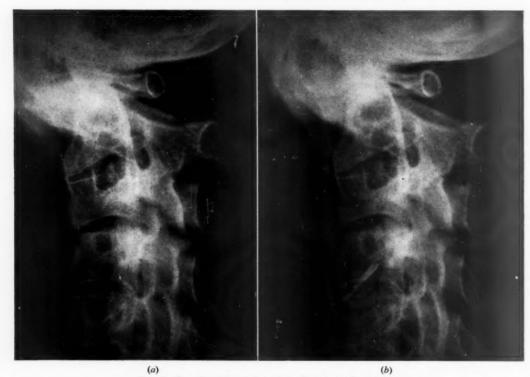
Case 7; radiographs: (a) in flexion, (b) in extension.
